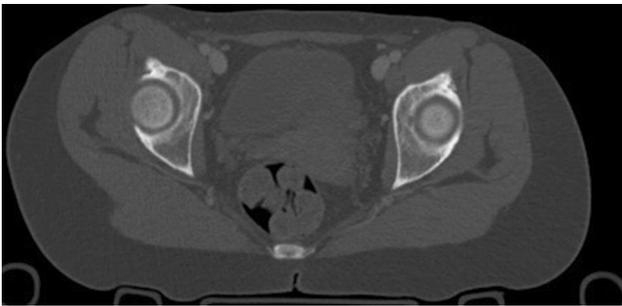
CT scan of Type II variant of the AIIS—defined as bony prominences on the ilium wall extending from the caudal area of the AIIS to the acetabular rim or sitting directly at the rim
